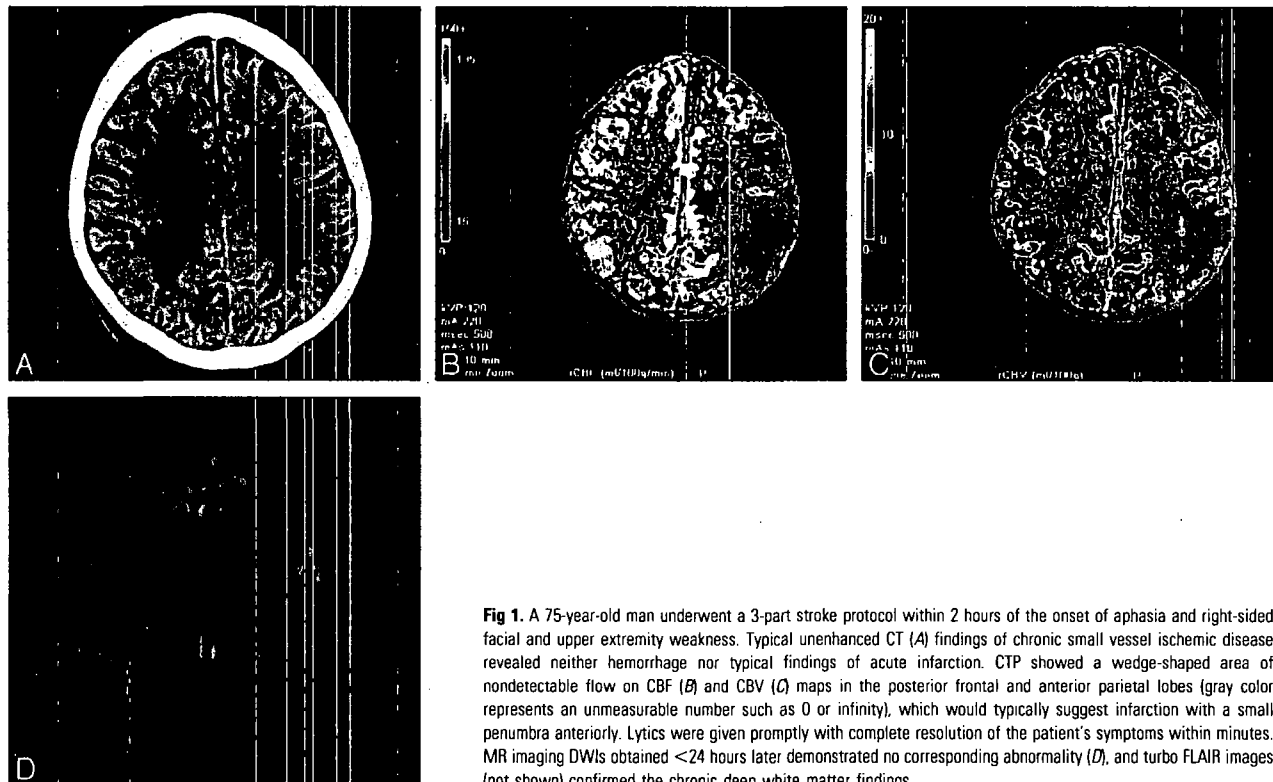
A 75-year-old man underwent a 3-part stroke protocol within 2 hours of the onset of aphasia and right-sided facial and upper extremity weakness. Typical unenhanced CT (A) findings of chronic small vessel ischemic disease revealed neither hemorrhage nor typical findings of acute infarction. CTP showed a wedge-shaped area of nondetectable flow on CBF (B) and CBV (C) maps in the posterior frontal and anterior parietal lobes (gray color represents an unmeasurable number such as 0 or infinity), which would typically suggest infarction with a small penumbra anteriorly. Lytics were given promptly with complete resolution of the patient's symptoms within minutes. MR imaging DWIs obtained <24 hours later demonstrated no corresponding abnormality (D), and turbo FLAIR images (not shown) confirmed the chronic deep white matter findings.
